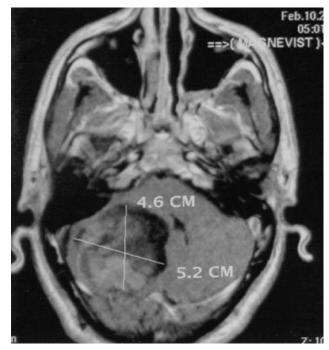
Showing MRI axial cuts of huge posterior fossa desmoblastic medulloblastoma.
